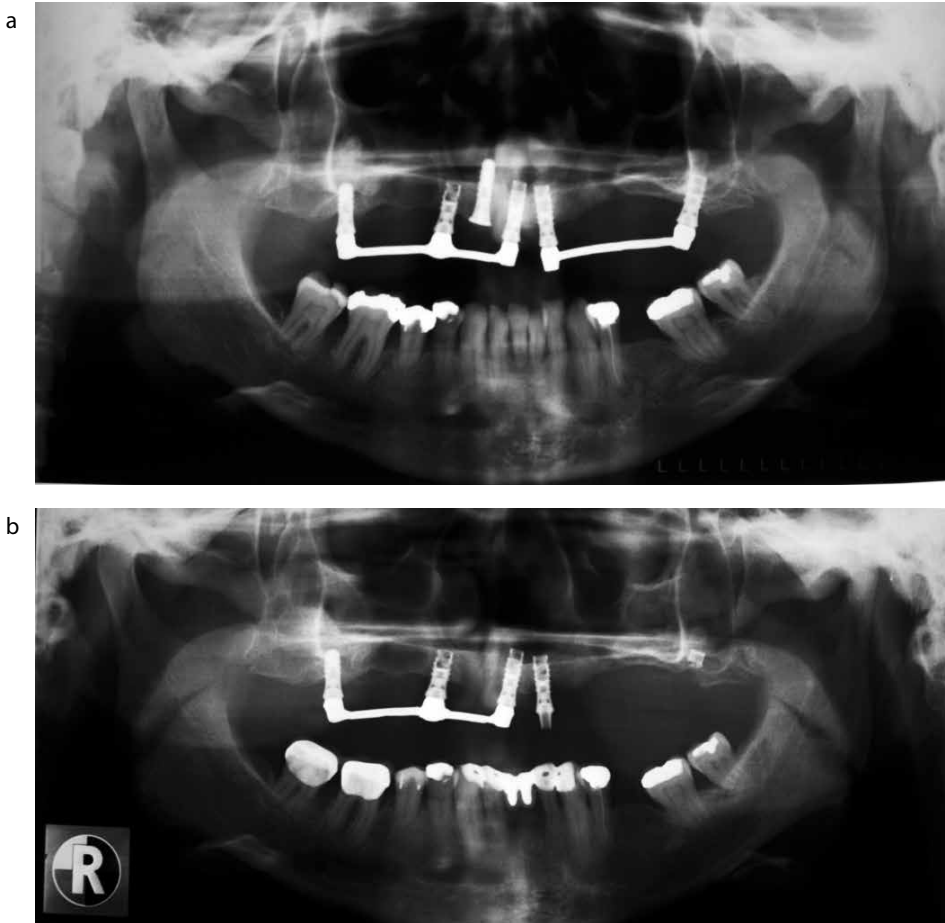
Sequence of radiographs showing UL7 implant buried with apical fragment left *in situ*.
